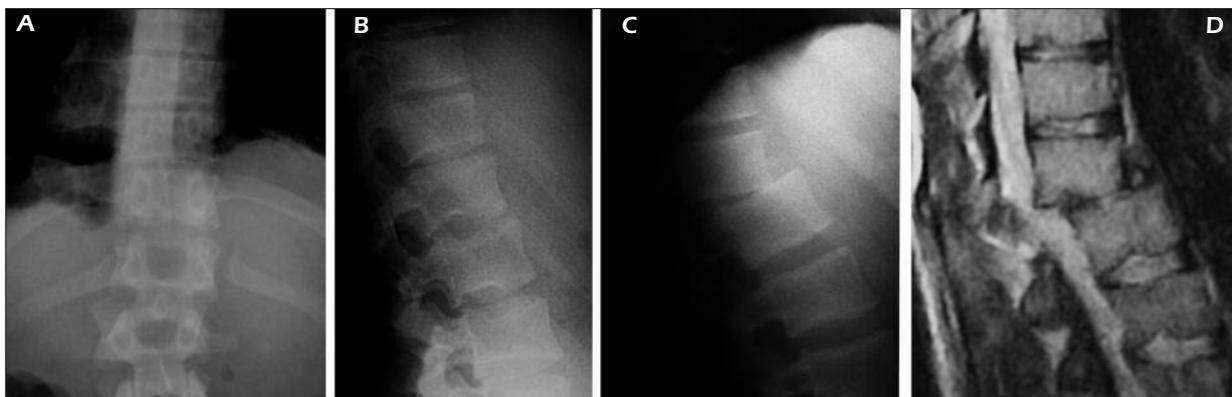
A-B*, Male, 21 yrs. High energy road accident. Unrecognized C-type fracture. No consideration was given to the lost alignment of the spinous processes and pedicles and to the dislocation of the 12th left rib. *C-D*, Standard radiogram and MRI three months later, after conservative treatment. Frank T12-L1 dislocation.
